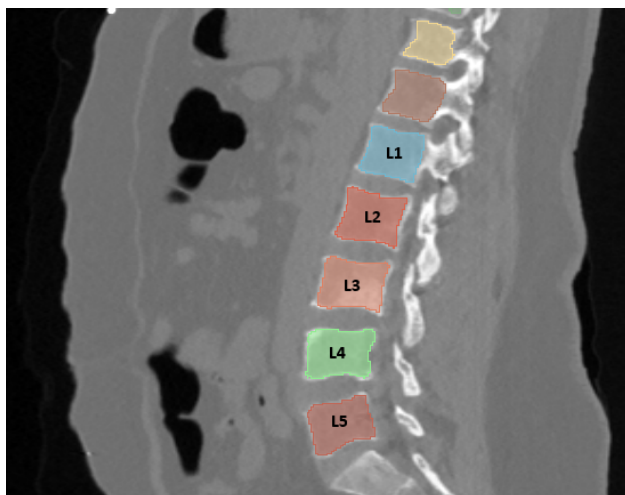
Lumbar vertebral bodies as seen on a sagittal CT scan.
